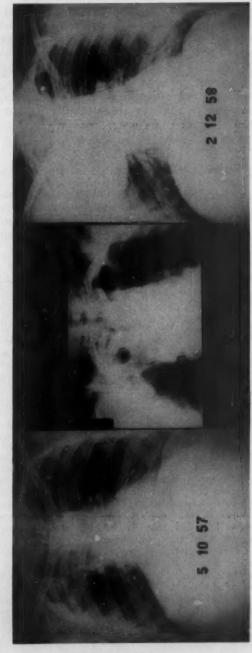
Case 6. Extraperiosteal plombage with paraffin filling used to control the disease of a 27 year old psychotic male who had had tuberculosis for four years and a spread in 1954 while on antimicrobial therapy. His sputum had remained positive and a cavity had persisted at the right apex Collapse was chosen because a pneumonectomy would have been necessary if resection had been performed. The sputum is now negative. (ieth Properative roenigenogram showing extensive disease on right. (center) Cavity at right apex well demonstrated on sectional radiogram. (right) Prostoperative roentgenogram showing density produced by the extraperiosteal paraffin filling on right.
